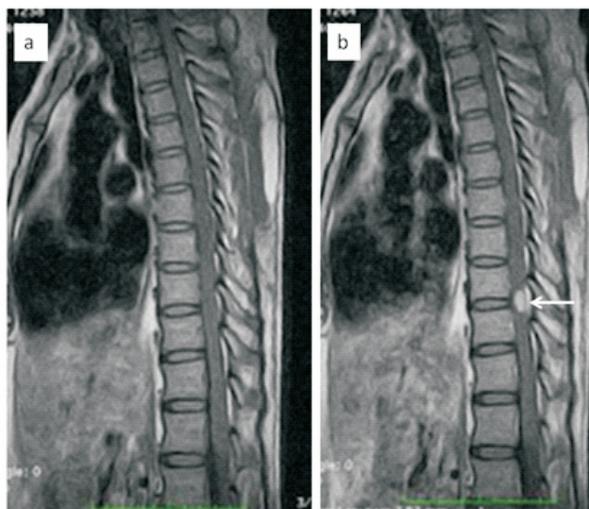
Sagittal T1 (a) and T1+C (b) thoracic spine magnetic resonance imaging of patient 2 showing a T9/T10 contrast enhancing intramedullary tumour (arrow)
